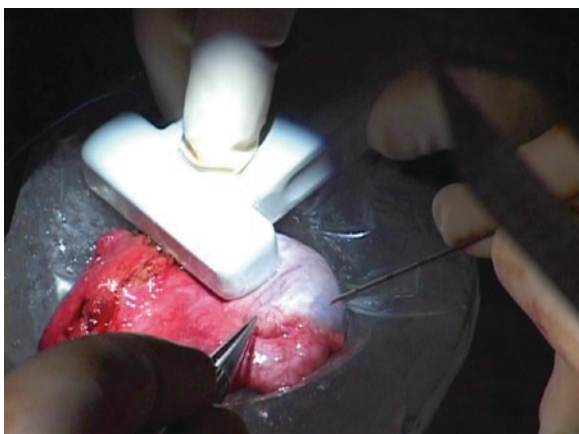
Linear ultrasound transducer at 15-MHz guides real-time intraoperative placement of the stereotaxic hook-shaped needle adjacent to the nodule. The 30-gauge stereotaxic hook-shaped needle that permits the hook to be completely contained in and pass through the needle lumen. The introducing needle can thus be optimally positioned prior to engaging the hook. The hook is ejected and released from the needle tip reforming to the hook and anchoring into the tissue adjacent to the tumor
